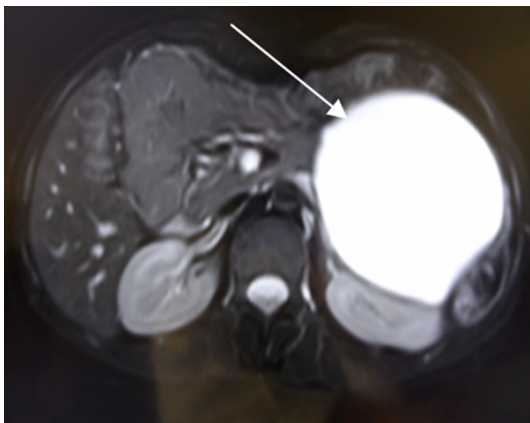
MRI indicated the giant retroperitoneal cyst.
